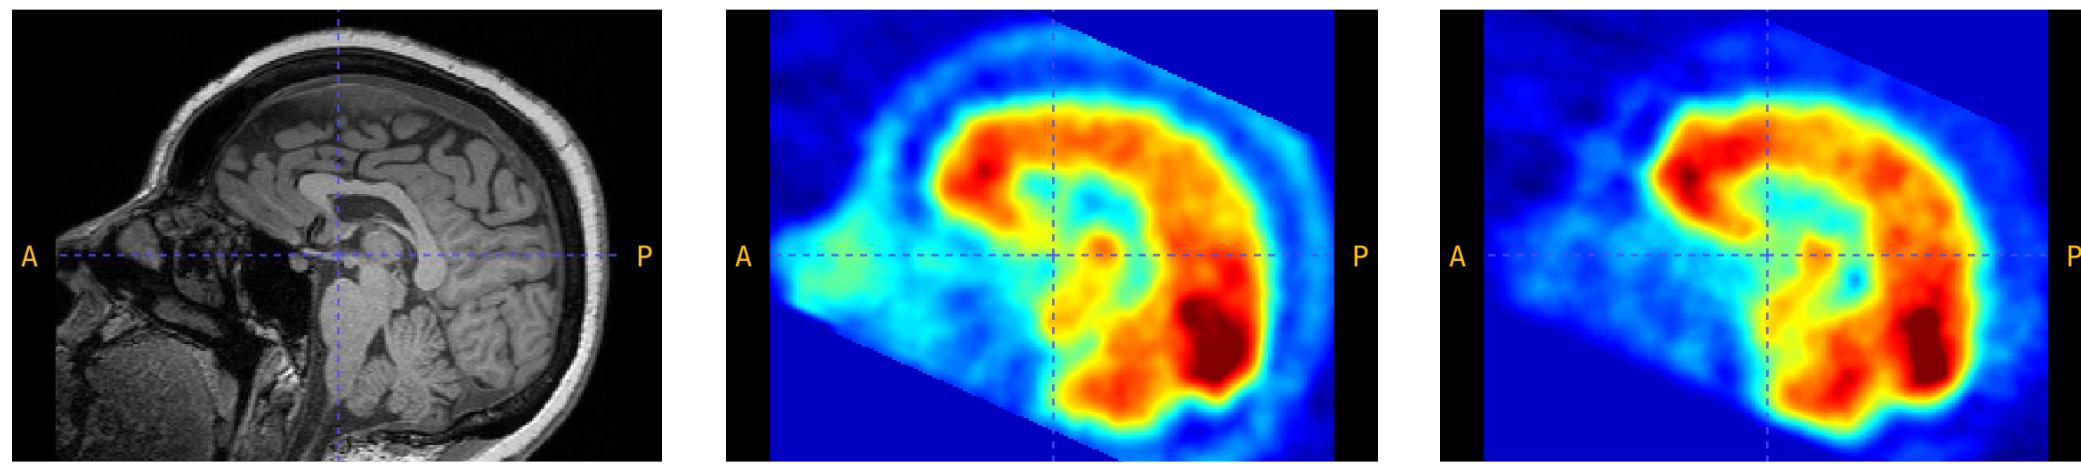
Sagittal cuts of the MRI (left), interictal SPECT (middle) and ictal SPECT (right), realigned and co-registered to the subject's MRI space.
